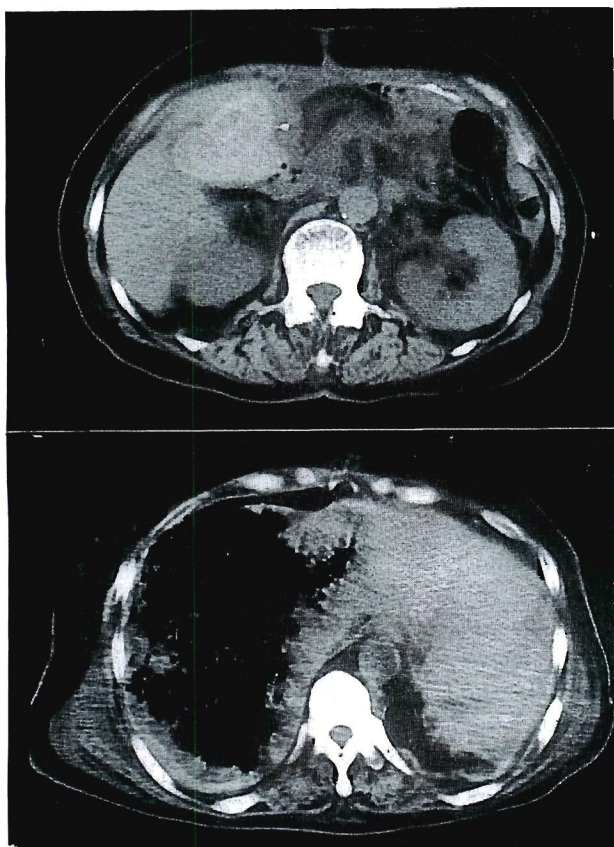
CT scan demonstrated a high density lesion (top) and a large low density lesion (bottom) within the liver.
